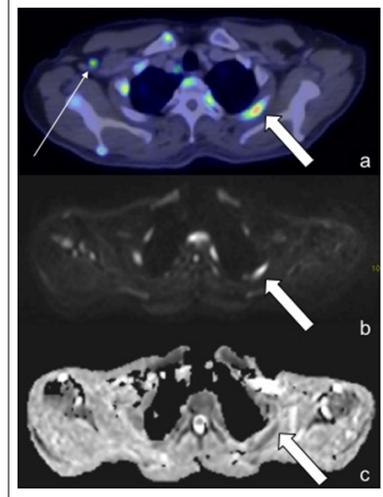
A 65-Year-Old Female with DLBCL. PET/CT Demonstrated Increased Uptake in the Mediastinal Nodes (a, Thin Arrows), However, these were not even Visualized on WB-DWI (b,c). In Contrast, the Right Axillary Node (Thick Arrows) were Positive on both Modalities (a-c).
